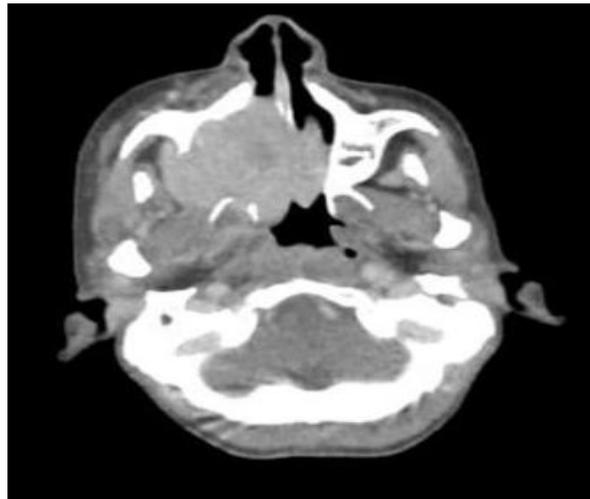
CT scan (axial view) of patient with right maxillary synovial sarcoma extending intranasal & destroying the infraorbital wall
